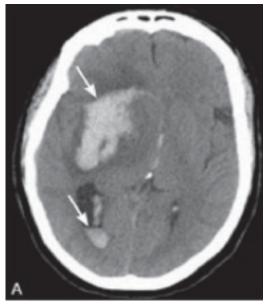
CT scan of brain showing acute intracerebral haemorrhage with midline displacement (Note: Acute haemorrhage appears hyperdense, i.e. white on CT scan)
